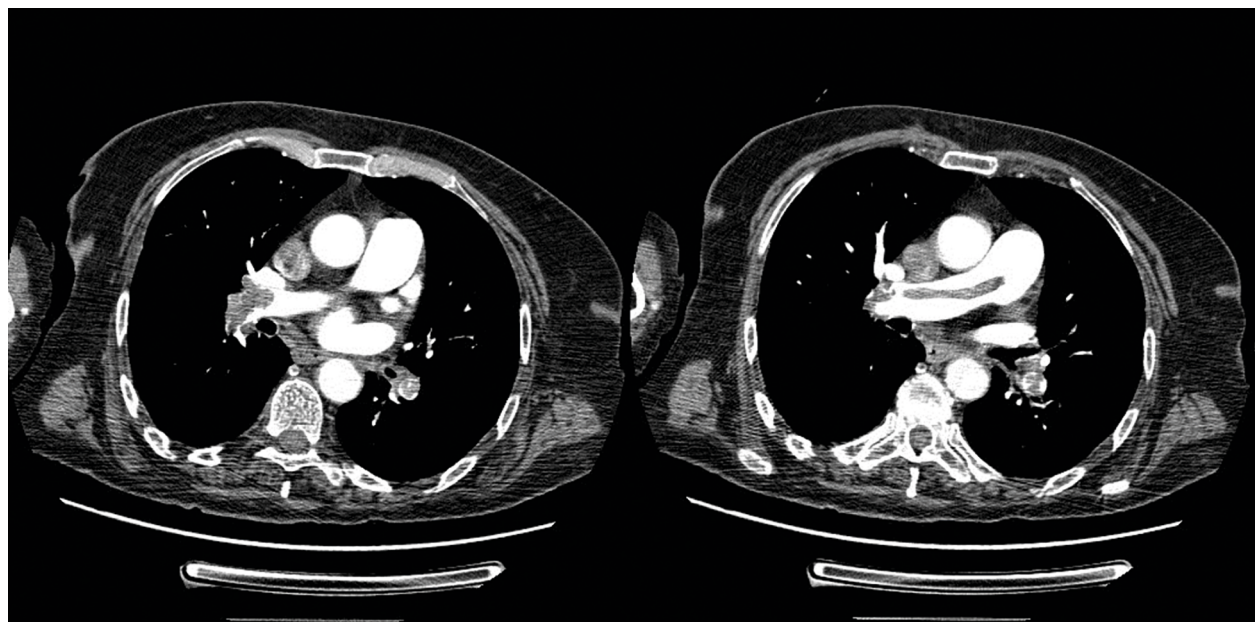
Computed tomography of the thoracic arteries – angiographic study – a band of embolic material in the pulmonary trunk division, penetrating the right pulmonary artery, present in the division.
